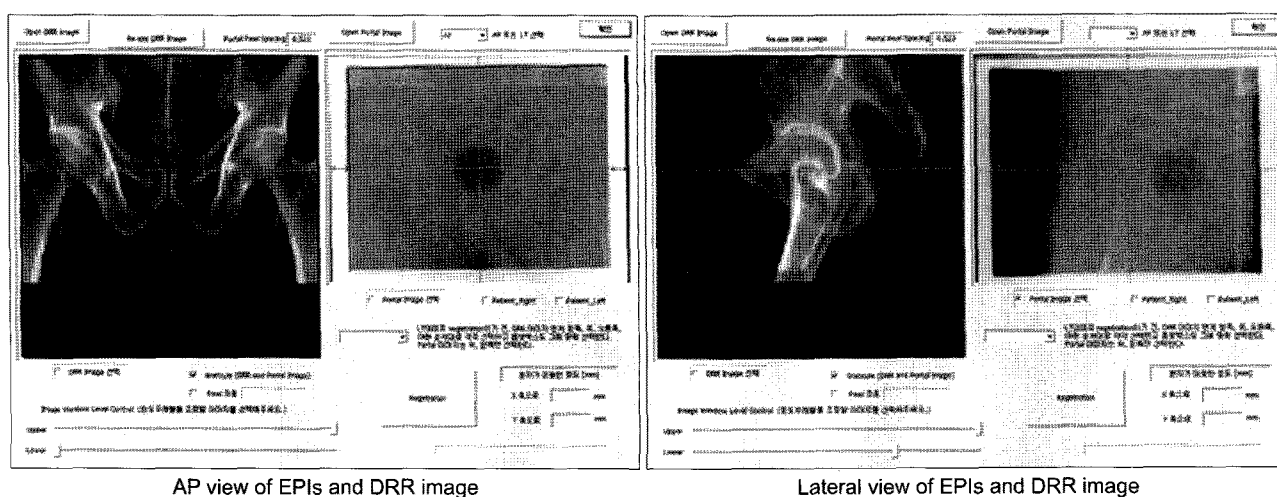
Image registration using an in-house program written in C++. AP: anterior-posterior, EPI: electronic portal images, DRR: digital reconstructed radiographs.
